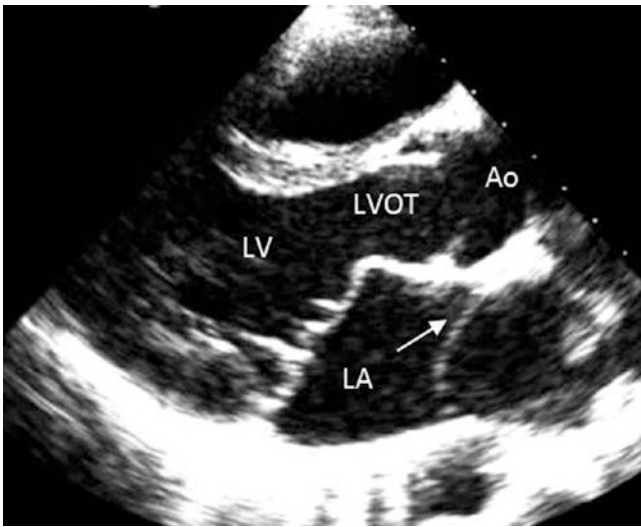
Parasternal long axis POC imaging of a 32-year-old man with new onset of atrial fibrillation. A flap-like structure (arrow) is found at the left atrium (LA), which separates the LA into two distinct chambers. This is highly suspicious for cor triatriatum, which was confirmed on subsequent transesophageal echocardiography. *LV* left ventricle, *LA* left atrium, *Ao* aorta
